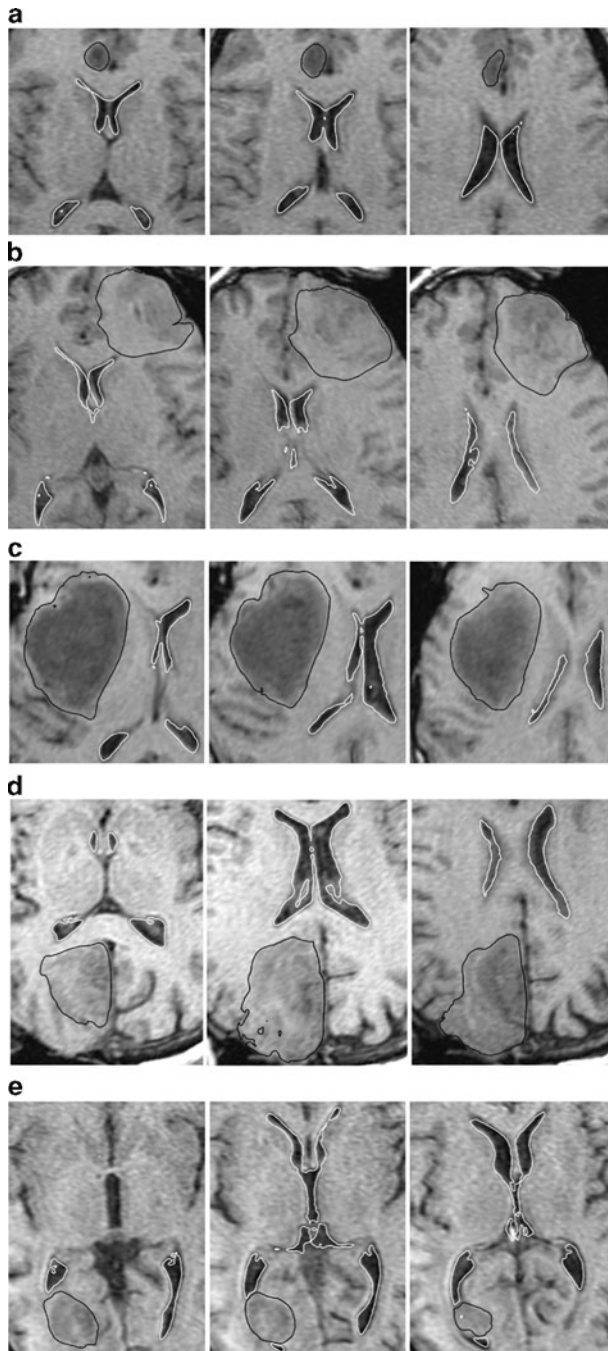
The registered (i.e. deformed using the calculated deformation field) pre-operative contours of ventricles (*white lines*) and tumor (*black lines*) imposed on the intra-operative MRI. Three transverse image sections are presented for each case, selected so that the tumor and ventricles are clearly visible. The images were cropped and enlarged. (a) Case 1; (b) Case 2; (c) Case 3; (d) Case 4; and (e) Case 5. For Case 2 (*row B – left-hand-side figure*), note the differences between registered contours and intra-operative image in the third ventricle area
